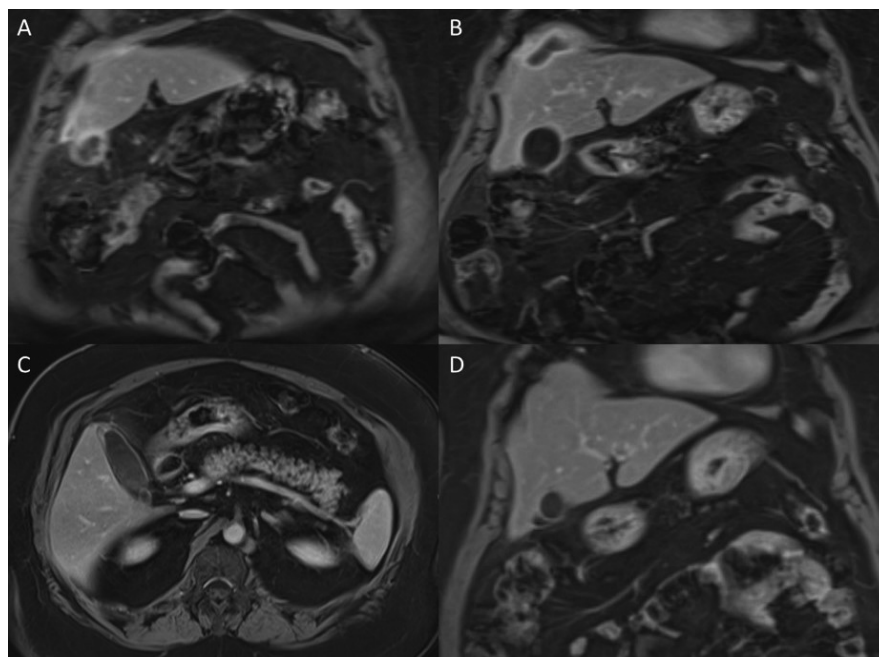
One day later, an extension of the collection, which is continuous with the gallbladder, to the perihepatic region and abscess formation/loculated collection at the subdiaphragmatic level were observed in postcontrast coronal VIBE images in cholangiopancreatic magnetic resonance imaging (MRI). (A, B). Antibiotic and intravenous fluid therapy were initiated. Two weeks later, neutrophil levels (4,200/μL), CRP (4.79 mg/L), direct bilirubin (0.18 mg/dL), ALP (78 U/L), and GGT (57 U/L) decreased. Two months later, a cholangiopancreatic MRI was performed for the control. In the postcontrast axial VIBE image, focal wall thickening and increased contrast were observed at the fundus of the sac (C). In the coronal sections, it was observed that the existing collection in the previous examination was lost in the vicinity of the gallbladder and subdiaphragmatic area (D).
